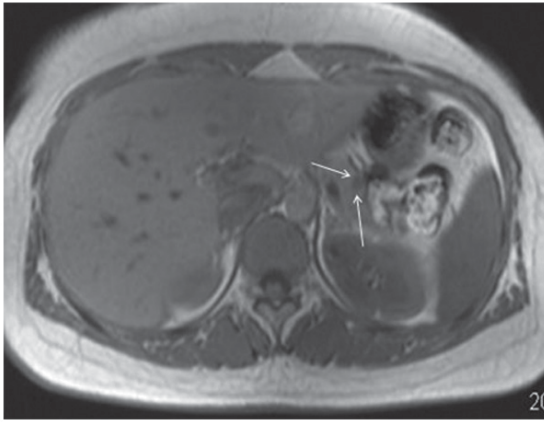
Lesion exhibiting a slow signal on axial T1-weighted images (arrows).
